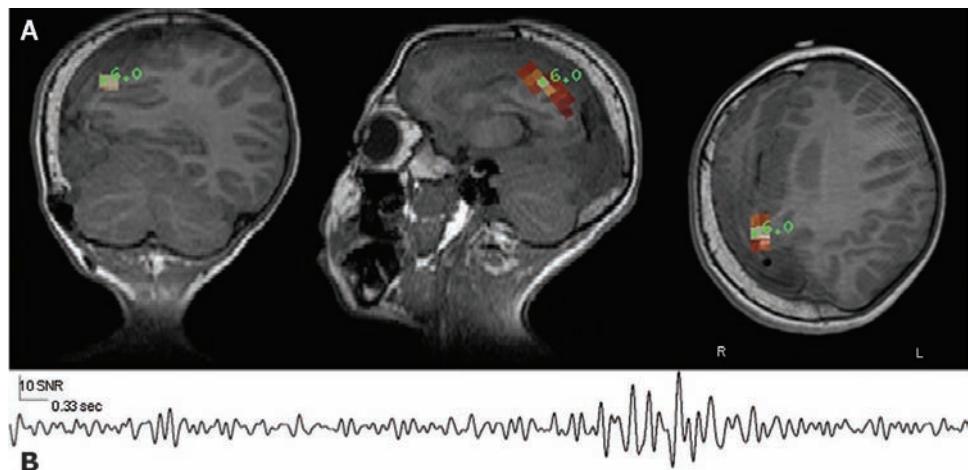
(A) A child with a severely dysplastic right cerebral hemisphere and marked parenchymal loss. Using a beamformer approach, significant abnormal low-frequency slow wave activity is localized to perilesional tissue in the right hemisphere, indicating compromised but active tissue. (B) Plotted below the MRI, a virtual sensor placed at the center of the localized slow wave activity shows activity at this location across time. Abbreviation: MRI, magnetic resonance imaging.
